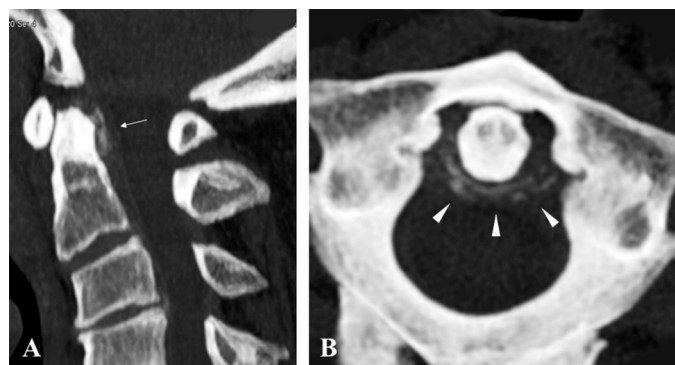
Cervical computed tomography (CT) scans around the odontoid process. Sagittal reconstruction showing the linear calcification at the posterior side of the dens suggesting calcium pyrophosphate dehydrate (CPPD) (white arrow) (A). The axial image demonstrates the right-dominant, half-ringed form of calcification at the posterolateral side of the dens (white arrowhead) (B).
